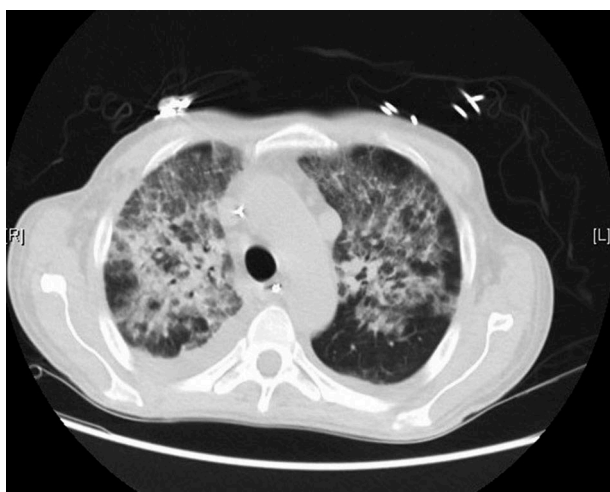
Chest CT image of liver transplant recipient with bilateral adenovirus pneumonia showing interstitial and airspace opacities of the upper lobes.
